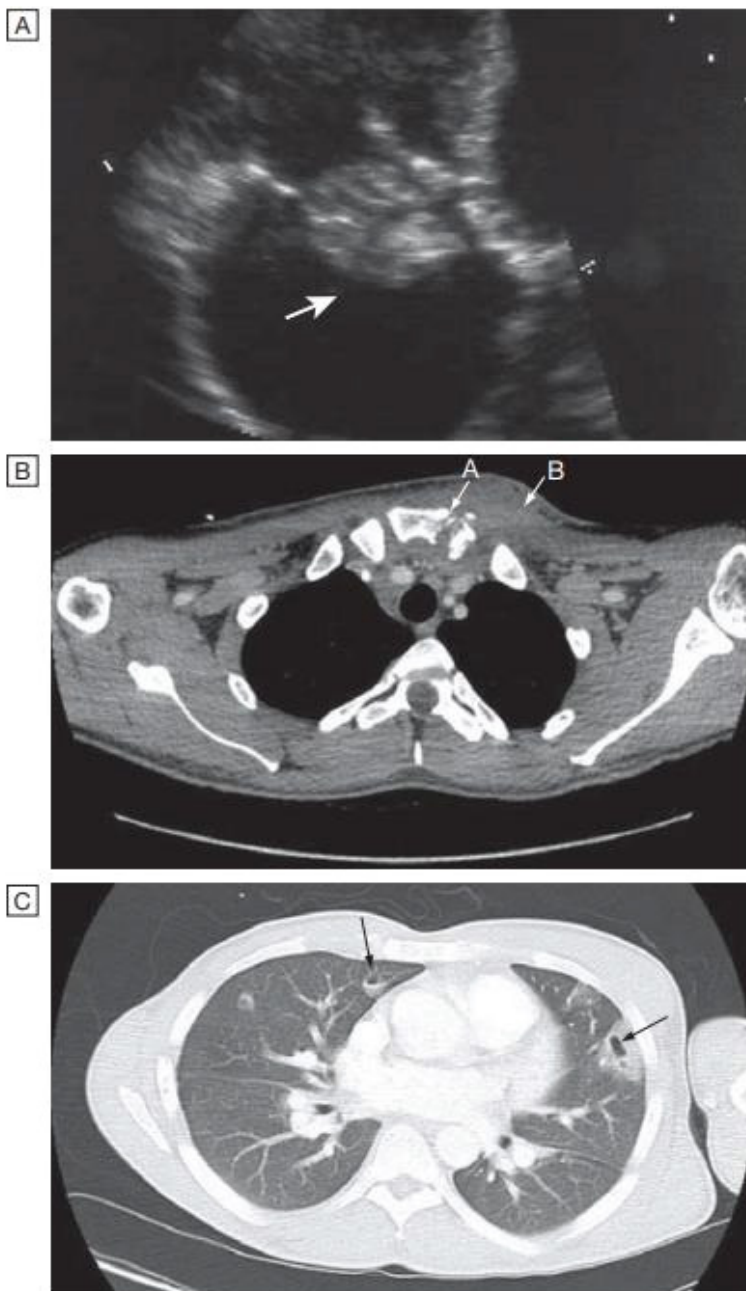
Causes of fever in injection drug-users. A Endocarditis: large vegetation on the tricuspid valve (arrow). B Septic arthritis of the left sternoclavicular joint (arrow A) (note the erosion of the bony surfaces at the sternoclavicular joint) with overlying soft tissue collection (arrow B). C Tricuspid valve endocarditis caused by *Staphylococcus aureus*. Thoracic CT scan shows multiple embolic lesions with cavitation (arrows). The patient presented with haemoptysis. C, Courtesy of Dr Julia Greig, Royal Hallamshire Hospital, Sheffield.
